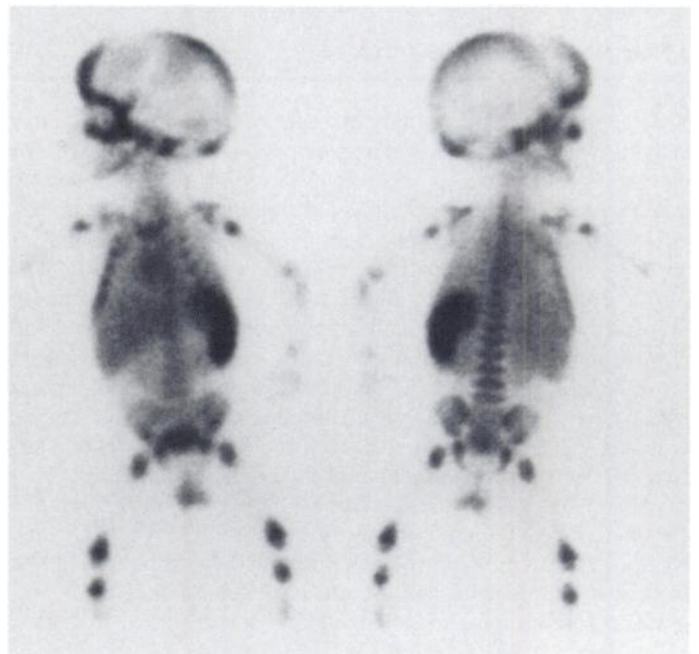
Whole-body bone marrow immunoscintigraphy shows tracer accumulation in large part of skeleton demonstrating good therapy outcome after BMT.
